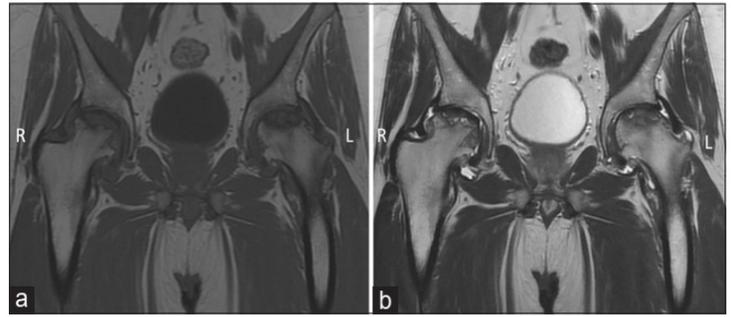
Coronal images of MRI scan of the bilateral hip joints showing geographical heterogeneous low signal intensity areas replacing normal marrow signal in the femoral heads suggestive of avascular necrosis (a, T1-weighted; b, T2-weighted). MRI: Magnetic resonance imaging
